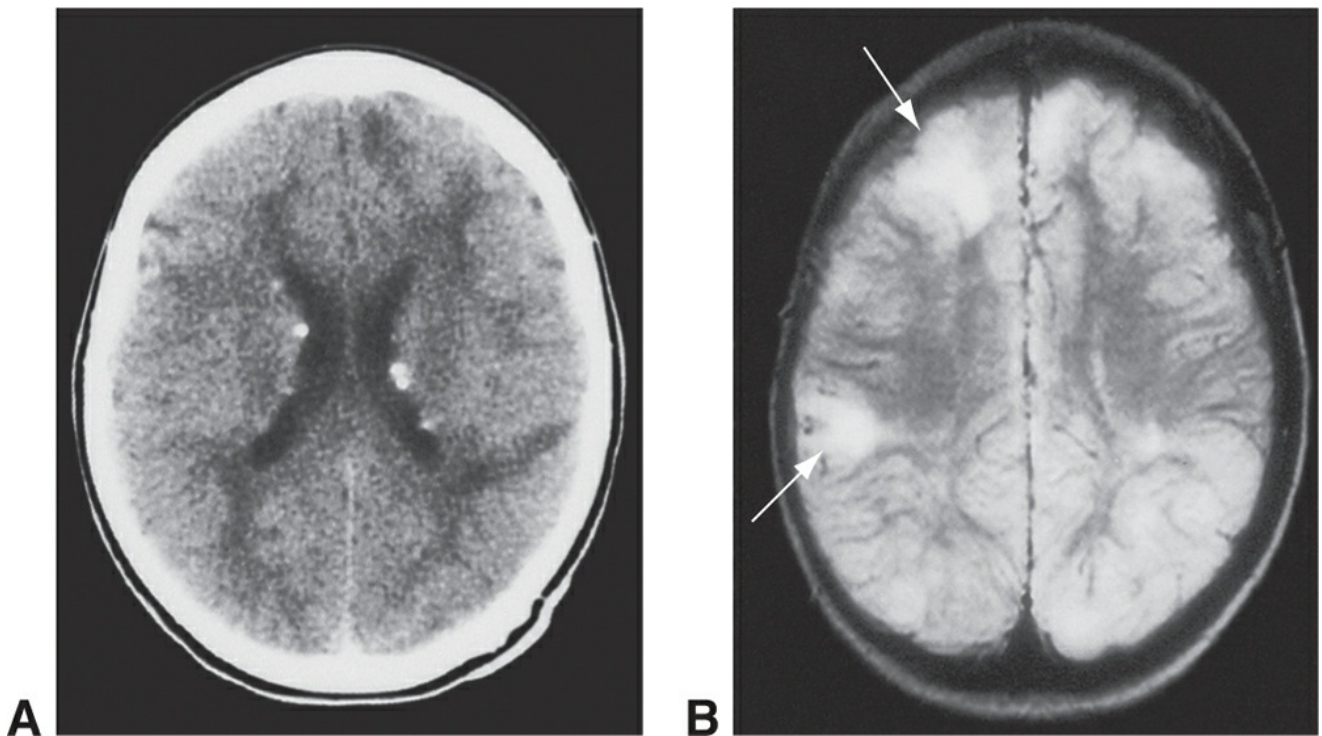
Brain lesions of tuberous sclerosis. A, Axial computed tomography image showing small periventricular calcifications. B, Axial T2-weighted MR image demonstrating tuberoses malformations (arrows).
